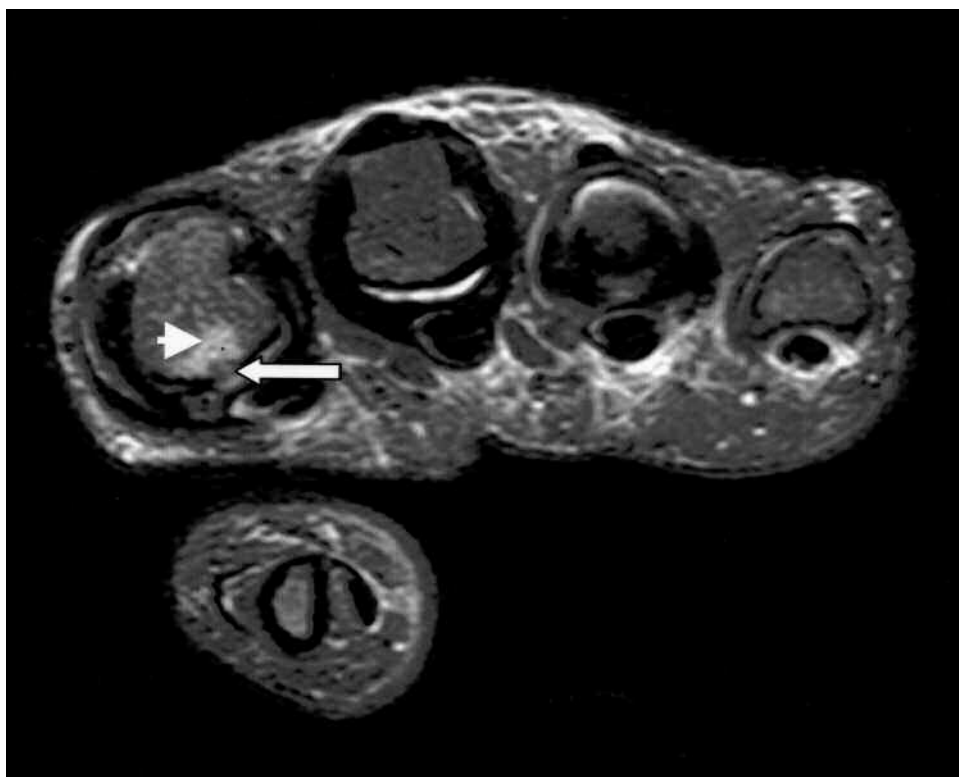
A. Enhanced MRI image of metacarpophalangeal (MCP) joints (Patient 4). Arrowhead: bone edema; long arrow: flexor tenosynovitis; short arrow: synovitis. B. MRI/STIR image of MCP joints (Patient 2; hand radiographs showed no erosions). Arrowhead: bone edema; long arrow: bone erosion.
